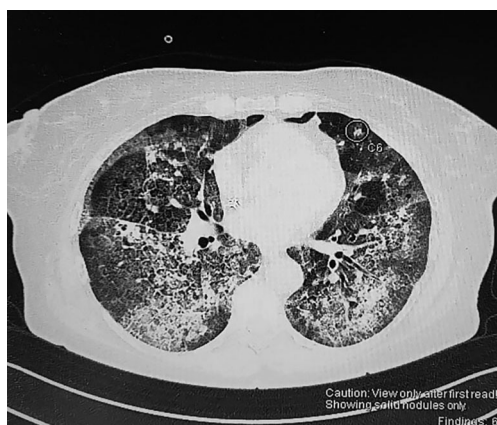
Thoracic computed tomography image of advanced interstitial lesions with diffuse alveolar hemorrhage
